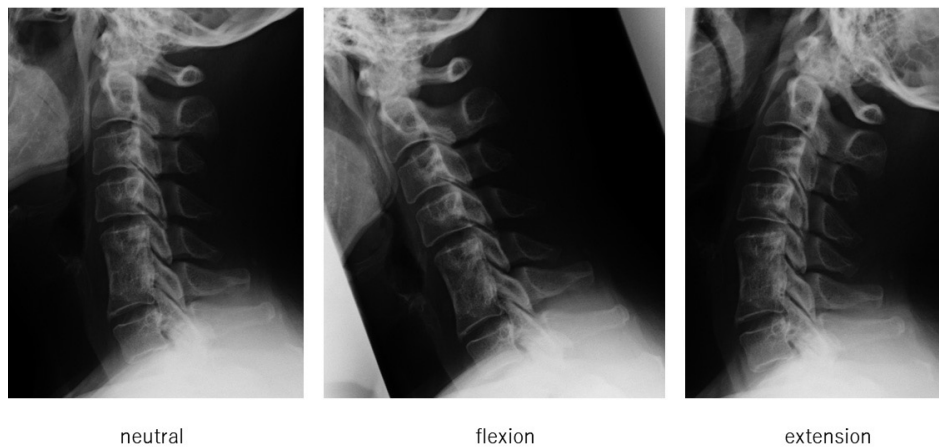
Follow-up computed radiograph (CR) studies at 4 years after initial ACDF without plate fixation. CRs showed cervical lordotic alignment with preserved cervical motion without instability.
